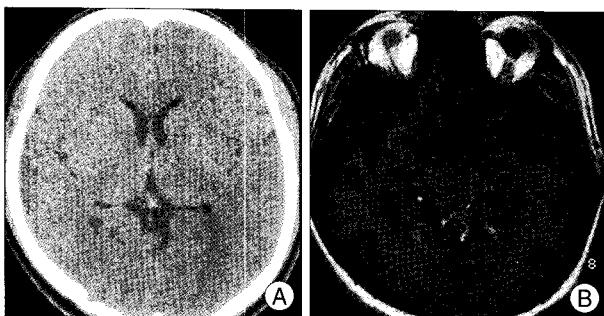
Preoperative computed tomography and magnetic resonance imaging showing multiple fat droplets in the basal cistern and lateral ventricle.
